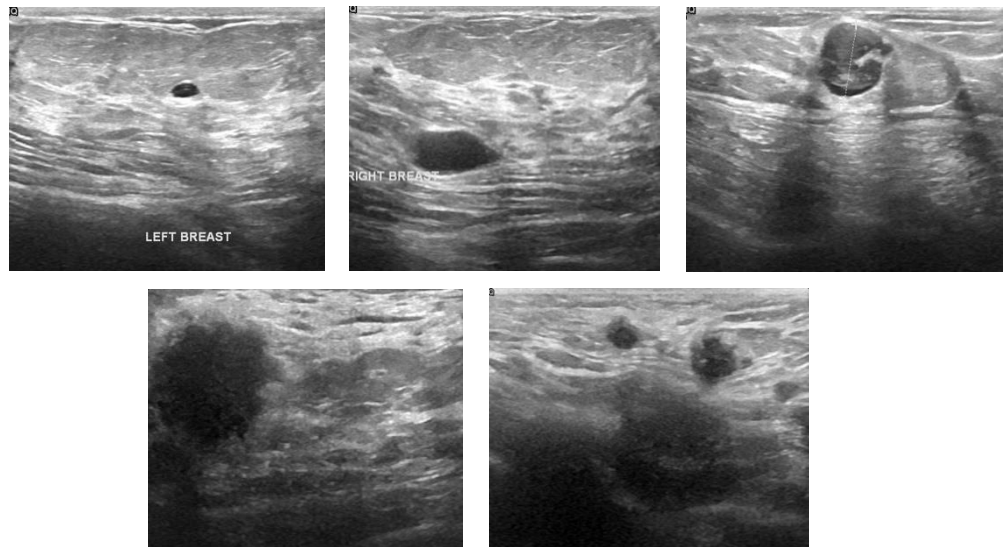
Ultrasound images (From top left: benign, benign, malignant, malignant, malignant)
